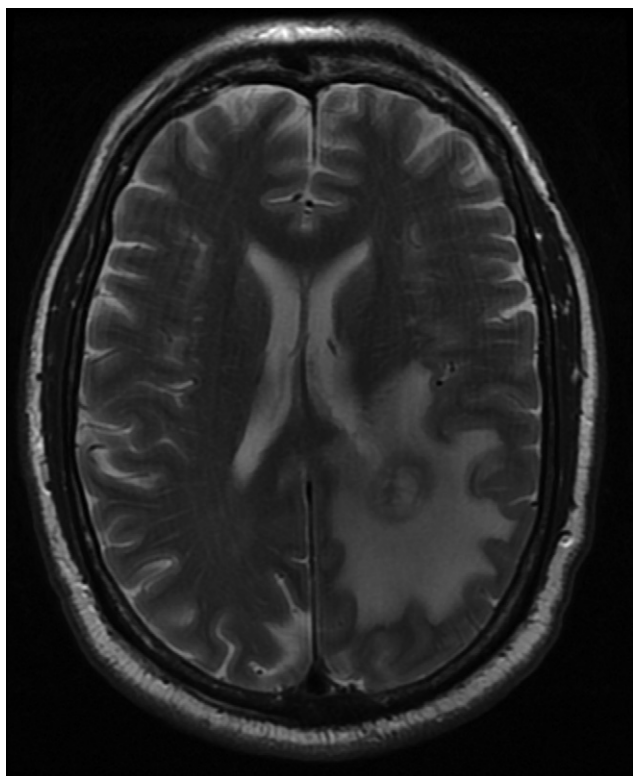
Magnetic resonance imaging of the brain of the index case with *N. farcinica* brain abscess. A heterogeneous rim-enhancing lesion is seen within the left parietal periventricular white matter with surrounding vasogenic edema.
